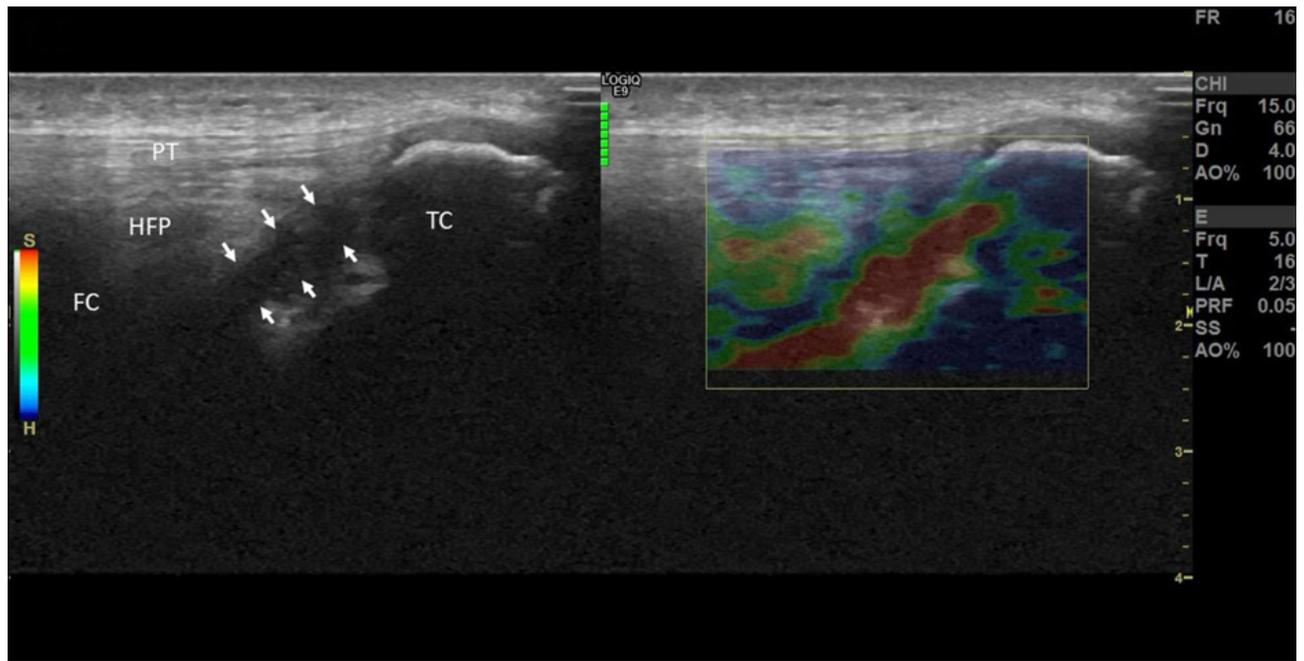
Postoperative longitudinal B-mode grayscale ultrasound and strain elastography images of the anterior cruciate ligament (FC: femoral condyle; TC: tibial condyle; PT: patellar tendon; HFP: Hoffa's fat pad).
